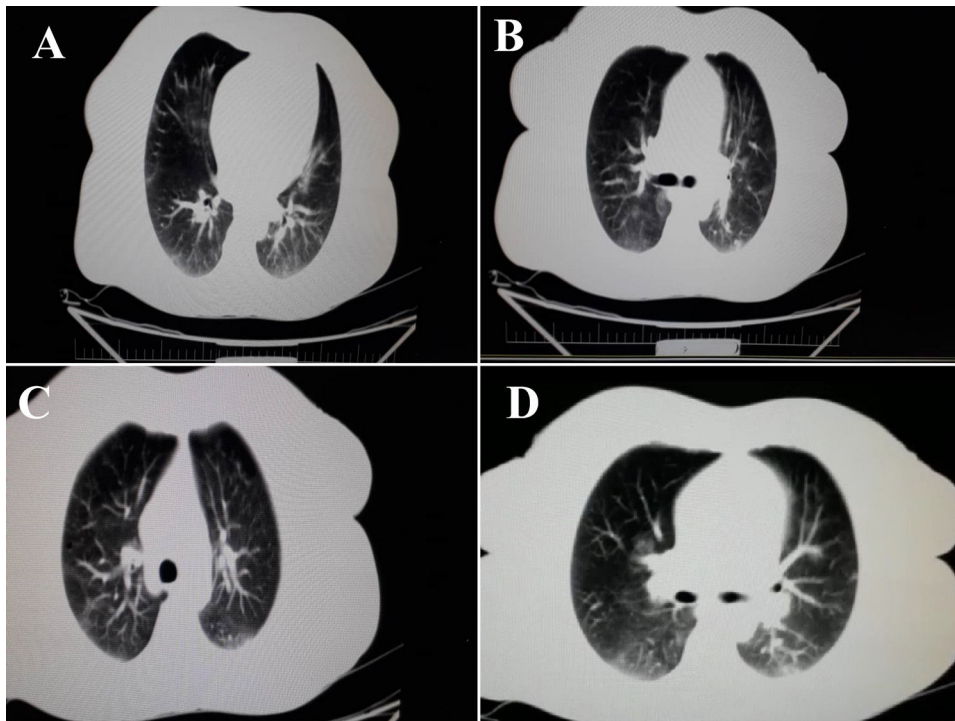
Chest CT scans (transverse plane) of 43-year-old woman with presentation of dysentery due to the infection with SARS-CoV-2. Chest CT resulted bilateral peripheral ground glass, crazy paving and small consolidation opacities.
